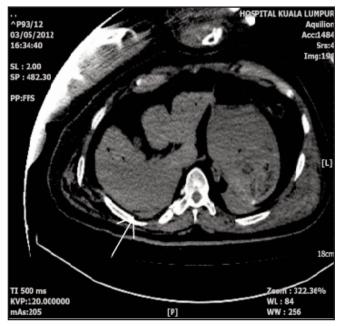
Axial view of plain post mortem CT scan of showing laceration at the posterior margin of right liver (arrow).
